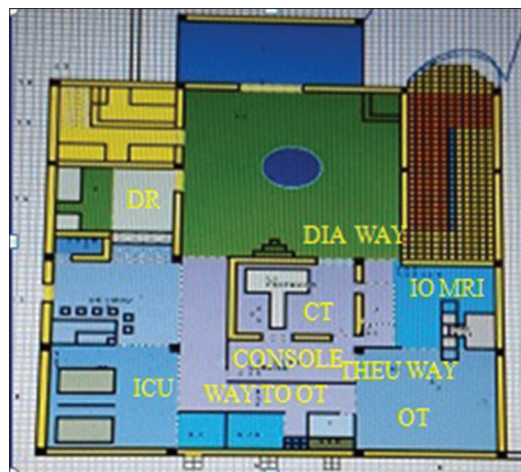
Setup of intraoperative magnetic resonance imaging, operation theater, computed tomography scan, and Intensive Care Unit
